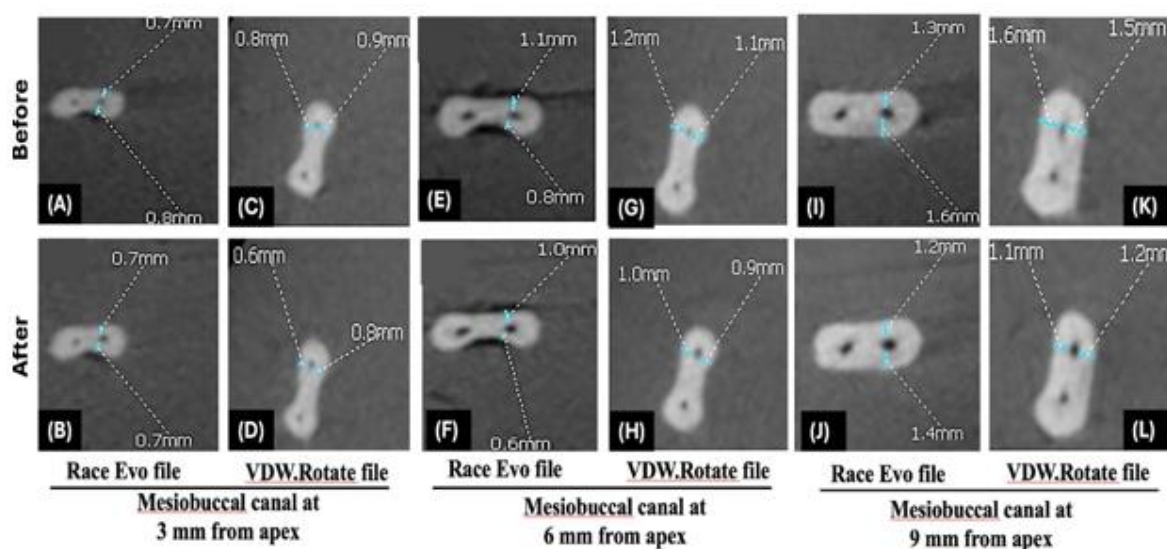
A CBCT image showing (A) Mesiobuccal canal at 3 mm from apex before preparation by using Race Evo file. (B) canal after preparation. (C) Mesiobuccal canal at 3 mm from apex before preparation by using VDW.Rotate file. (D) canal after preparation. (E) Mesiobuccal canal at 6 mm before preparation by using Race Evo file. (F) canal after preparation. (G) Mesiobuccal canal at 6 mm before preparation by using VDW.Rotate file. (H) canal after preparation. (I) Mesiobuccal canal at 9 mm before preparation by using Race Evo file. (J) canal after preparation. (K) Mesiobuccal canal at 9 mm before preparation by using VDW. Rotate file. (L) canal after preparation
